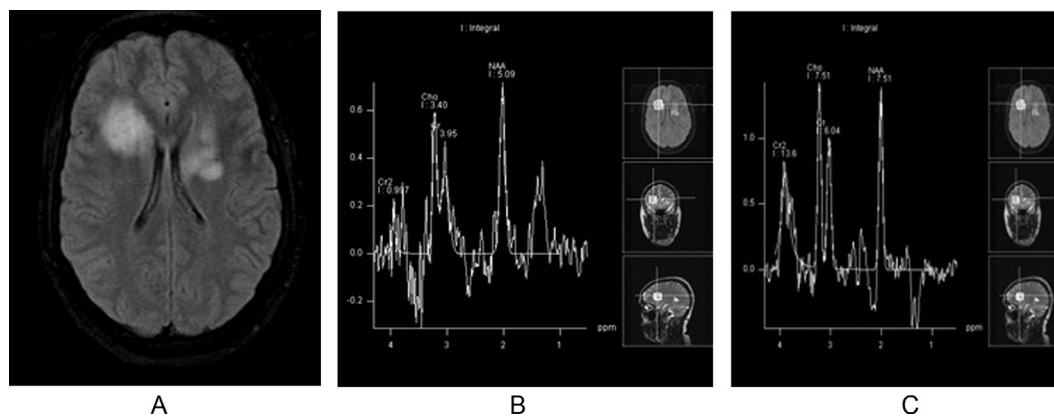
Child female patient 3 years old with leigh's disease: (A) MRI axial T2 FLAIR of the brain revealed bilateral deep white matter hyperintense lesion, (B & C) MRS at long and short TR showed: Elevated lipid/lactate peak, elevated Cho/crea ratio. NAA/Cr ratio was decreased.
